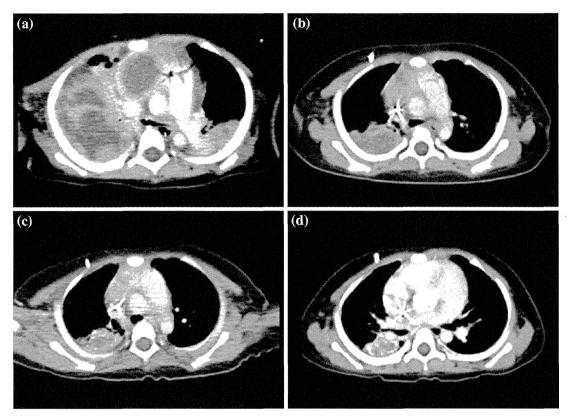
Computed tomography (CT) scans of patient 4, showing a large pulmonary and mediastinal masses in a patient with respiratory symptoms, including cough, wheezing, and tachypnea. A CT-guided needle biopsy was performed, confirming the diagnosis of diffuse, large-B-cell lymphoma. b CT after six cycles of rituximab and three cycles of cyclophosphamide and prednisolone chemotherapy showed reduction in the sizes of the pulmonary and mediastinal
